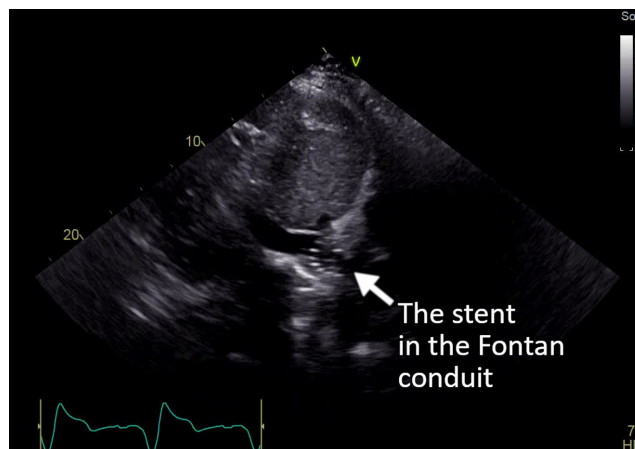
Transthoracic echocardiography, subcostal view: the Fontan conduit with the visible stent.
